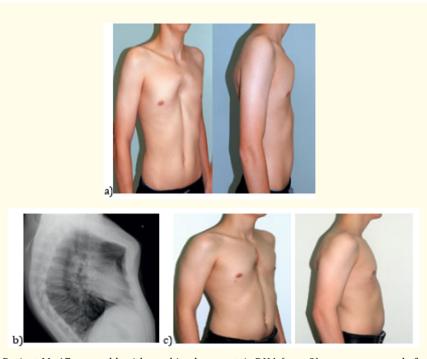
Patient M., 17 years old, with combined symmetric DHA (type 2). a - appearance before surgery; b - chest x-ray in lateral projection; c - appearance 3 months after operations.
